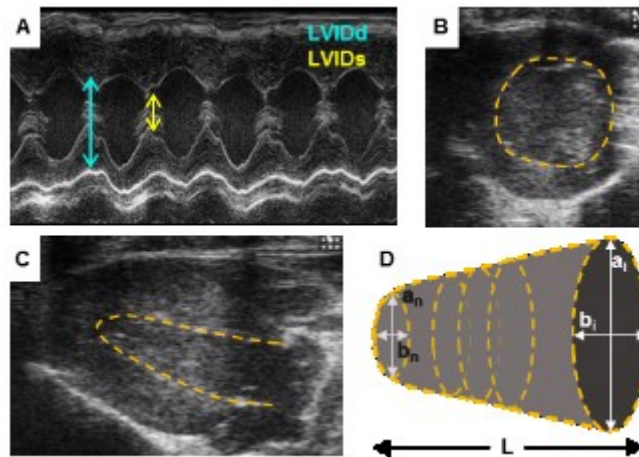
Determination of ventricular volumes by echocardiographic imaging.
